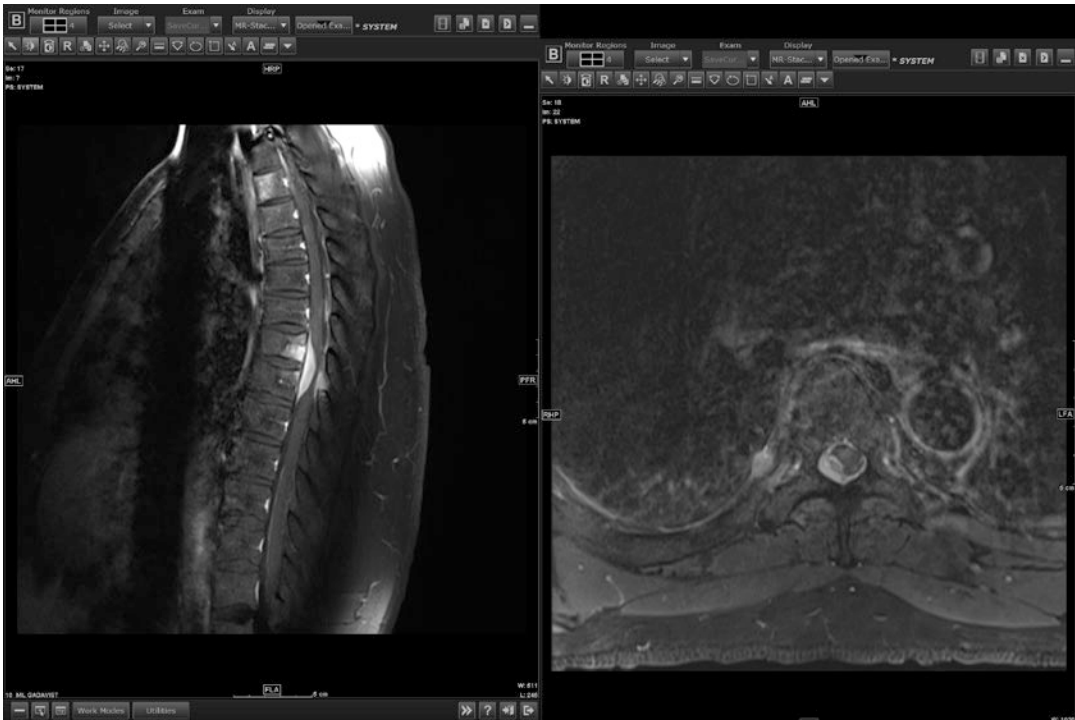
Rosai–Dorfman disease of the spine: sagittal/axial gadolinium-enhanced T1-weighted MRI shows an expansile dural-based mass with compression of the spinal cord (Courtesy of Dr. Eli Diamond, New York, USA)
